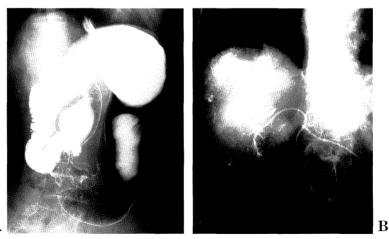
A: An upper gastrointestinal tract examination; Borrmann II type advanced gastric cancer in the lesser curvature of pyloric antrum is revealed. B: Plain abdominal roentgenogram after lipiodol TAE by Port-A-Cath. Note the uptake of lipiodol into metastatic liver tumors.
